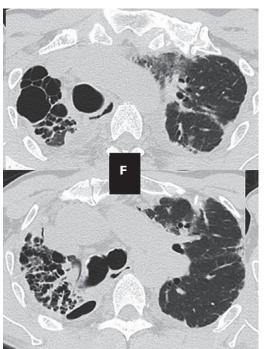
Changes in chest CTs (computed tomography) at the level of upper lobes and carina over time. Chest CT taken just before resection of renal cancer 64 months before onset (A); chest CT taken 6 months before onset (B); chest CT taken 9 months after onset (C); and chest CT taken 16 months after onset (D).
